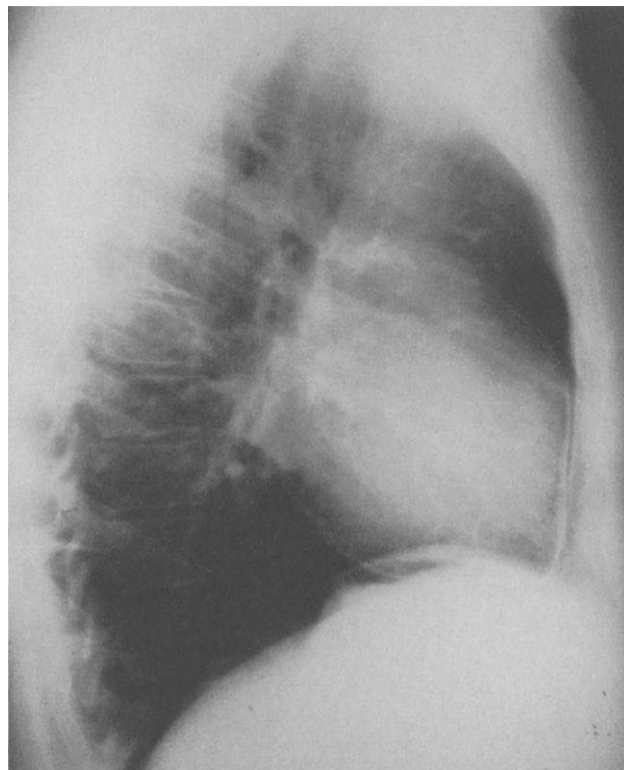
Preoperative lateral chest roentgenogram showing inferior pericardial calcification.
